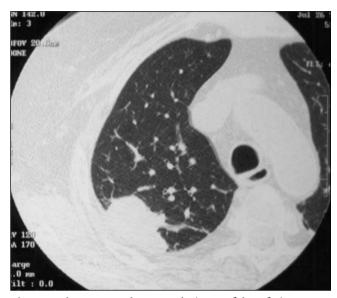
Chest computed tomography image of the soft tissue mass in the posterior aspect of the right upper lobe abutting the chest wall without obvious extension
